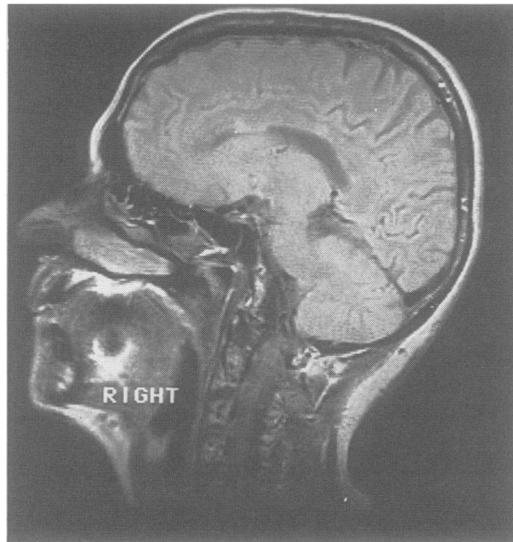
Case 4; T2 weighted sagittal MRI (SE TR 2000/TE 80) of the brain. There are multiple high signal lesions in the corpus callosum.
